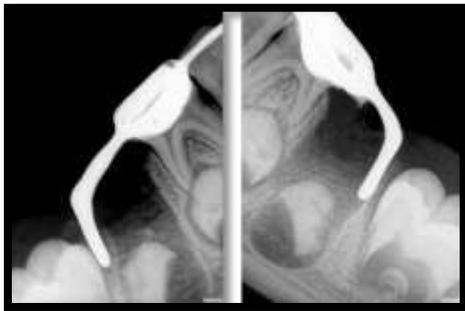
Periapical radiographs before cementation
